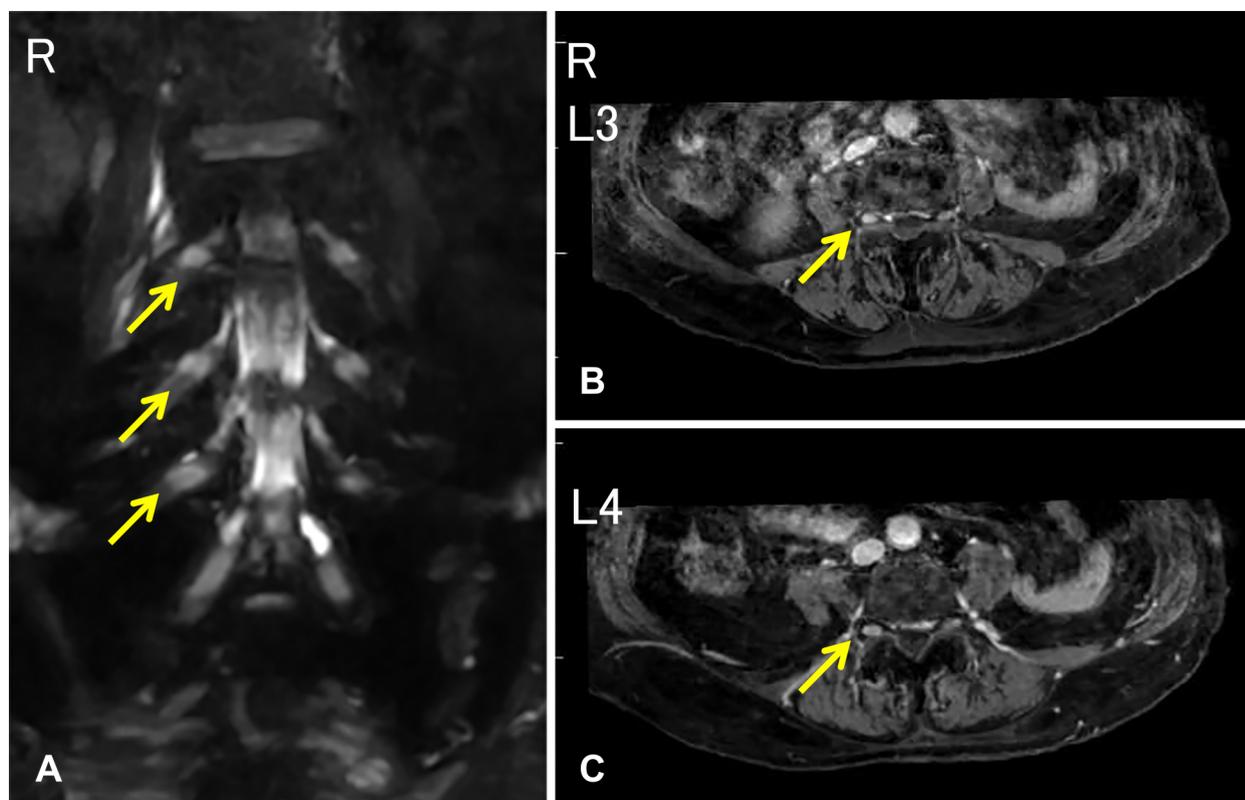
MRI findings in lumbar nerve roots.
